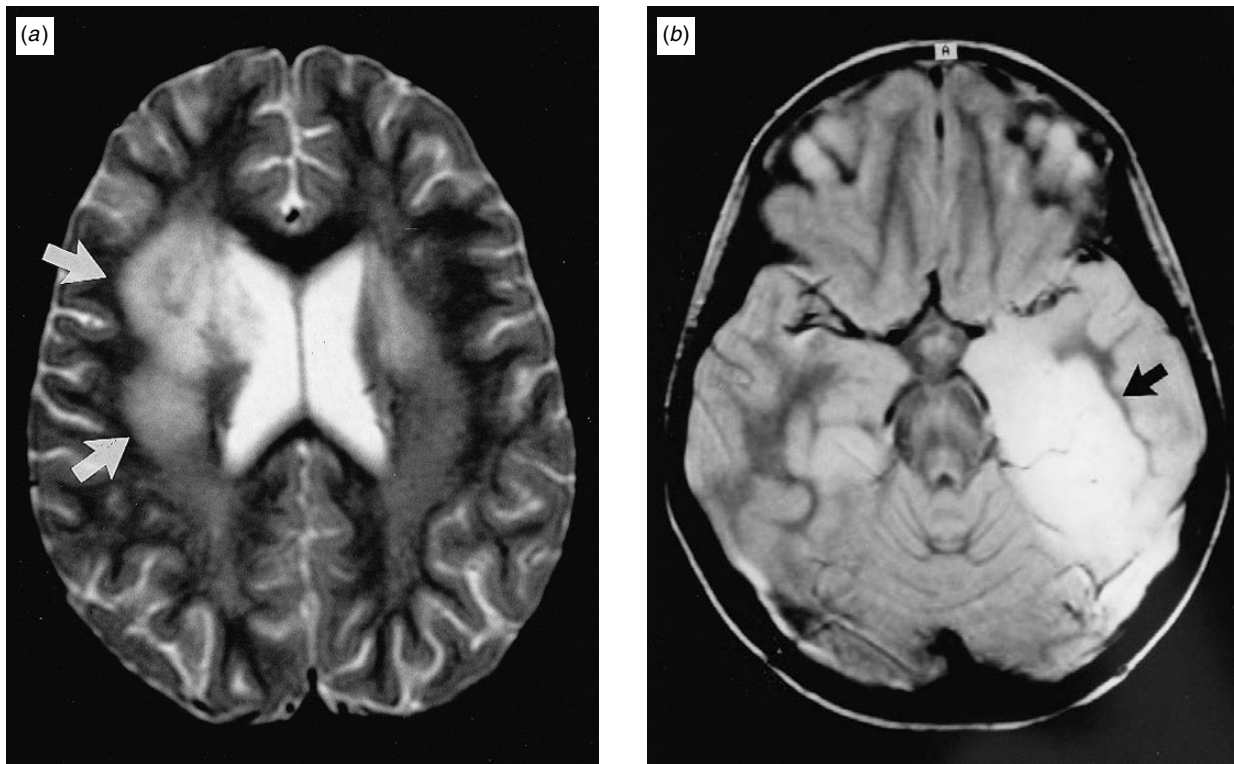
(a) Acute disseminated encephalomyelitis in a 13-year-old child: T₂-weighted magnetic resonance image demonstrates multiple hyper intense lesions in cerebral white matter. (b) Herpes simplex encephalitis in a 40-year-old man: T₂-weighted magnetic resonance image demonstrates hyperintense lesion in the mesial temporal lobe. (From Davis, 2000.)
